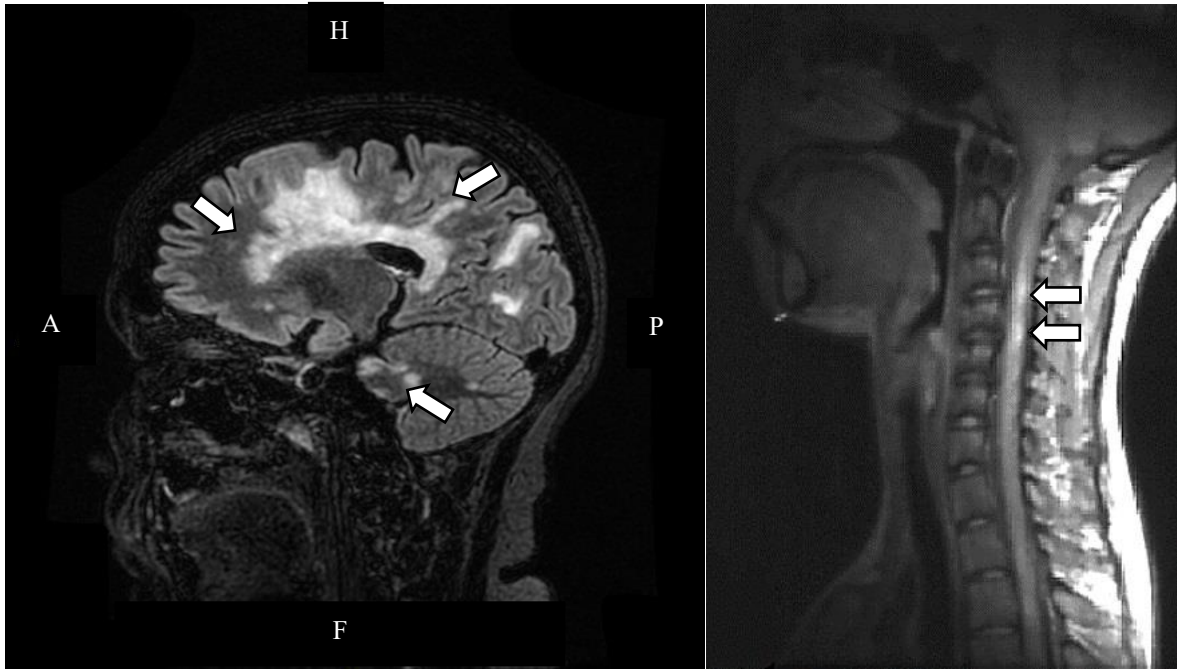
Brain (on the left) and spinal cord (on the right) MRI with multiple T2 lesions characteristic of MS indicated by white arrows
